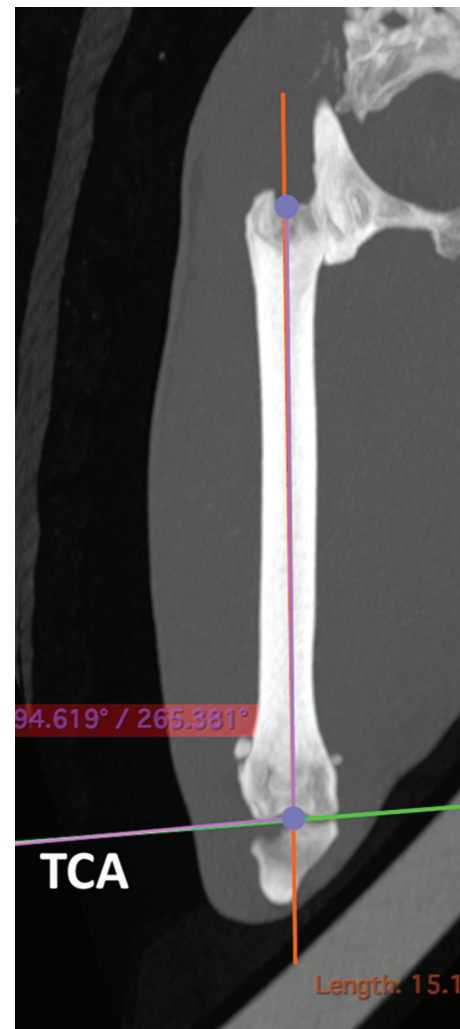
Frontal plane computed tomography scan demonstrating measurement of the anatomical lateral distal femoral angle (aLDFA). The transcondylar axis (TCA) was drawn intersecting both the medial and lateral femoral condyles. The aLDFA was measured as the angle between the transcondylar axis and the axis of the proximal femoral diaphysis as measured for angle of inclination of the femoral neck.
